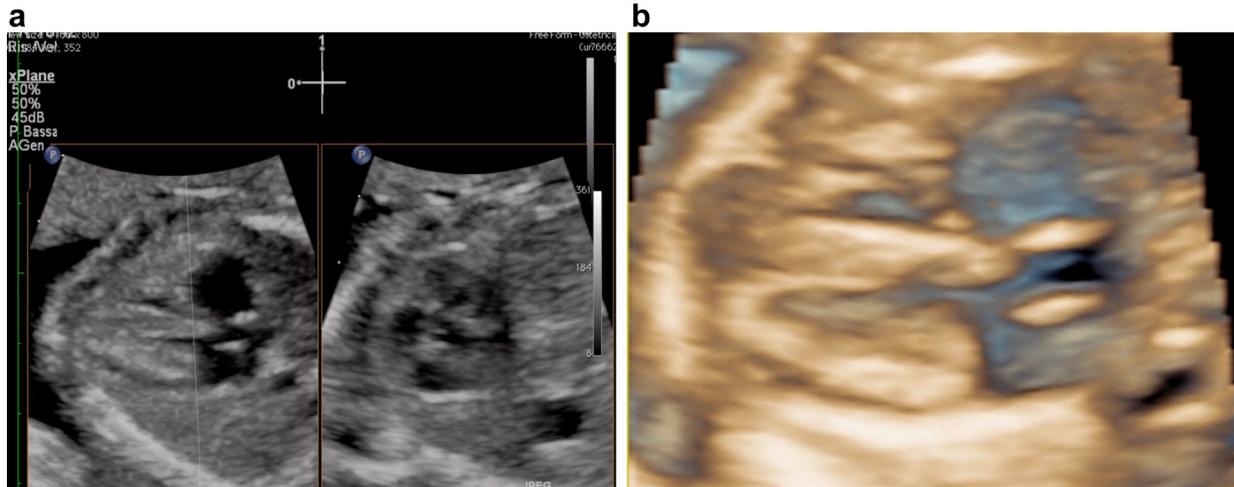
(a) Fetal echocardiogram using matrix array probe: Normal four-chamber view and great artery outflow tract by means of xPlane imaging. Note that the vertical line is drawn straight to cross the right ventricle, the tricuspid valve, the interventricular septum, the mitral valve and the left ventricle, respectively. (b) Four-dimensional sonogram revealing the four-chamber view.
